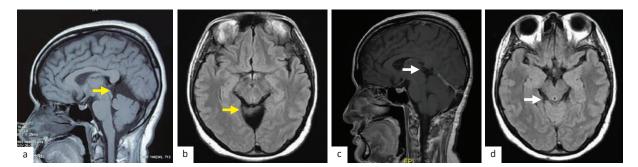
Preoperative non-contrast brain MRI of sagittal (a) and axial (b) views showing a hypointense lesion with a well-defined margin in T1WI that compressed cerebellar roof and tectal plate. An infratentorial extension confirmed the head CT findings of a type II quadrigeminal arachnoid cyst (yellow arrows) compared with the postoperative follow-up of the head MRI without contrast of sagittal (c) and axial (d) views that showed a complete resolution of the arachnoid cyst and a significant cerebellar roof decompression (white arrows). CT=computed tomography; MRI= magnetic resonance imaging; T1W1=T1-weighted images
